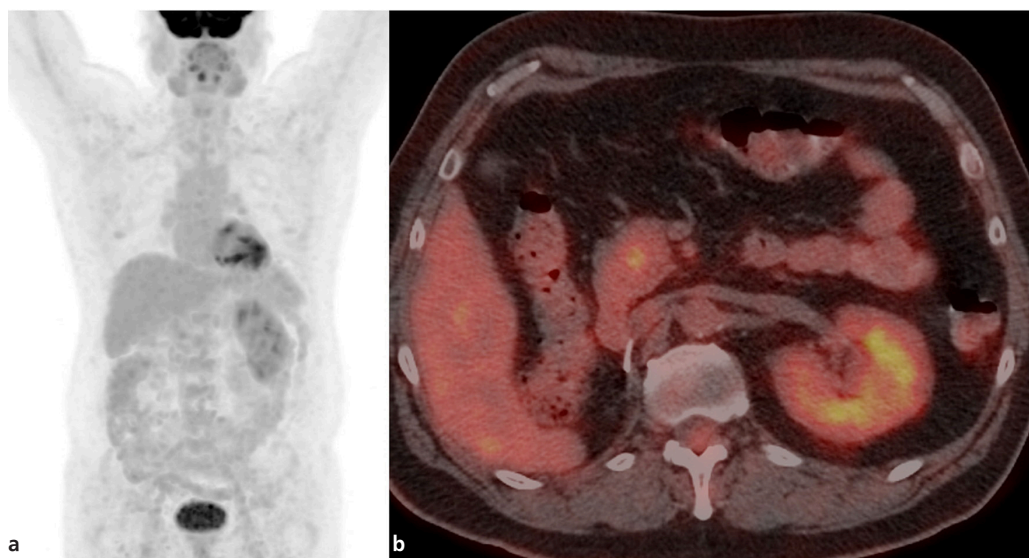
Fluorodeoxyglucose (FDG) positron emission tomography scan: pancreatic lesion is faintly FDG positive. The other lesions did not show substantial FDG uptake (should be borne on mind that the patient is under treatment at the time of the FDG scan). a. ^{18}F -FDG MIP image; b. ^{18}F -FDG axial hybrid imaging faint FDG uptake in the pancreatic lesion. To separate metastatic sites for both primaries, we attempted to use FDG PET/computed tomography (CT) (Figure 2) as a discriminator, as proposed in the literature (3). The scan was obtained after starting treatment for both and at PSA levels of 3.24 ng/mL. FDG was moderately positive for the pancreatic mass but not for the other locations (lung nodules were small volume) (Figure 2). On a size basis, there was no change in the pancreatic mass, but there was a reduction in the lung, mediastinal, and primary prostate sites, which additionally confused the interpretation. However, as a final decision, the patient had partial response for prostate cancer and non-progression (partial response or stable disease) for RCC and remained on the same treatment. This actually shows the inability of separating metastatic locations for all imaging modalities used (^{68}Ga PSMA, FDG, and CT) and the need for an individual approach and more complex clinical interpretation of the case.
